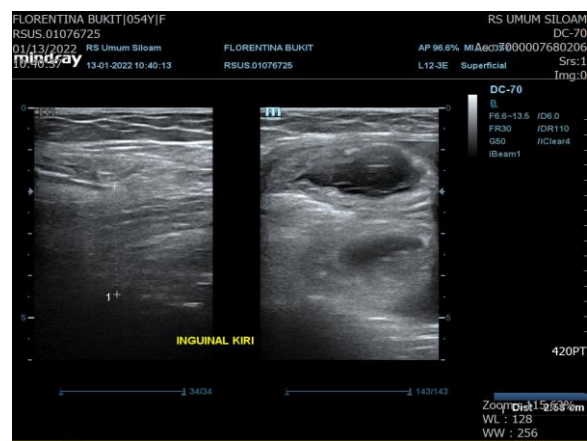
Abdominal ultrasound showed a left inguinal hernia with a defect of +/- 2,58 cm consisting intestinal tissues
